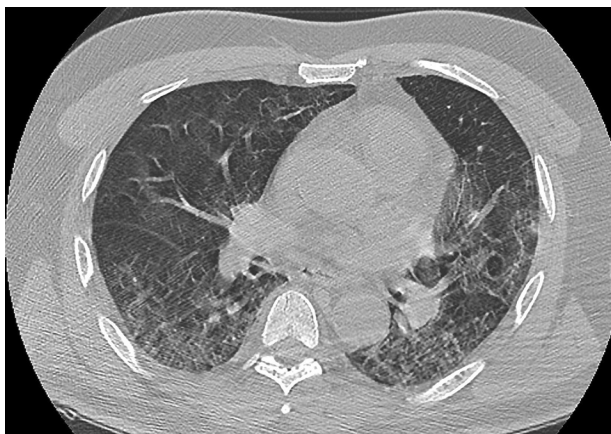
Chest CT scan in a patient with COVID-19 pneumonia and meningoencephalitis. Transverse thin-section CT scan on day 7 after symptom onset revealed bilateral, peripheral ground-glass opacities associated with crazy-paving pattern and subpleural lesions, predominant in the middle and lower lobes. There were no airway abnormalities, neither mediastinal lymphadenopathy nor pleural effusion. It is a typical image of a severe form (50% lung damage) of COVID-19 pneumonitis.
